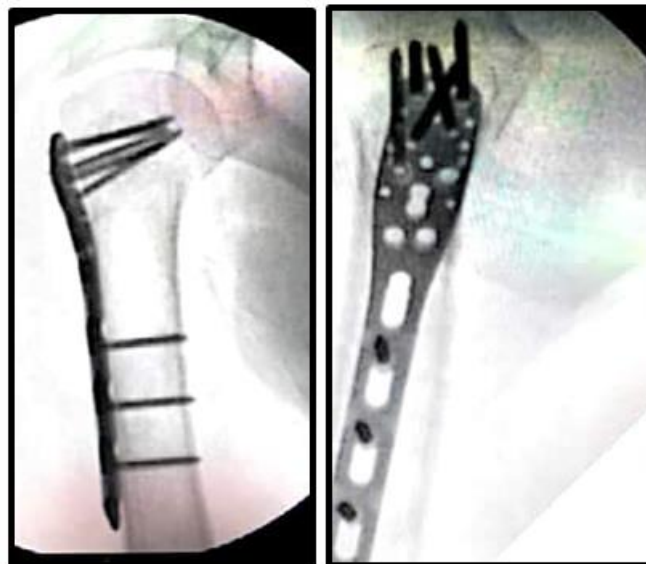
Immediate post-op X-ray C arm image AP and Lateral views
